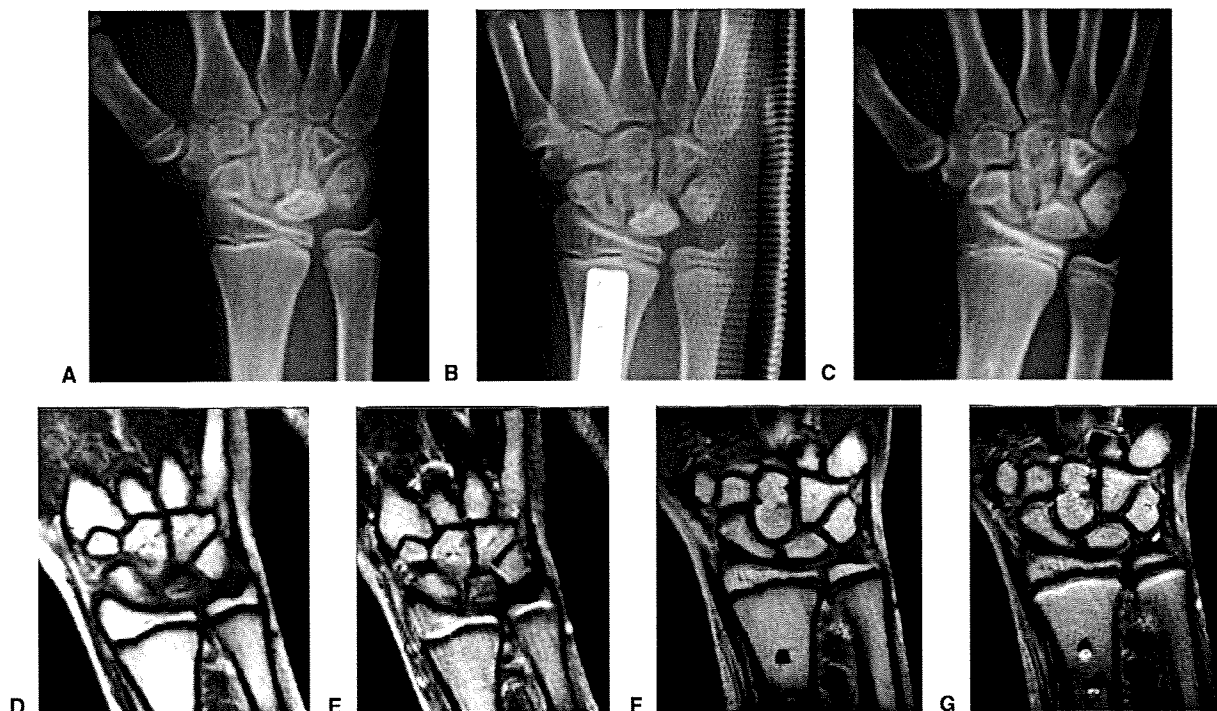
A A preoperative AP radiograph of an 11-year-old boy with Stage IIIA Kienböck’s disease in the right wrist. B The AP radiograph shows ulna-zero variance immediately after radial shortening. C The AP radiograph obtained 48 months after radial shortening indicates lunate revascularization with improved appearance of the lunate in density and height. D, E Preoperative coronal T1- and T2-weighted MRI images show diffuse decreased signal intensity of the lunate. F, G At follow-up, T1- and T2-weighted images demonstrate return of normal signal intensity of the involved lunate.
